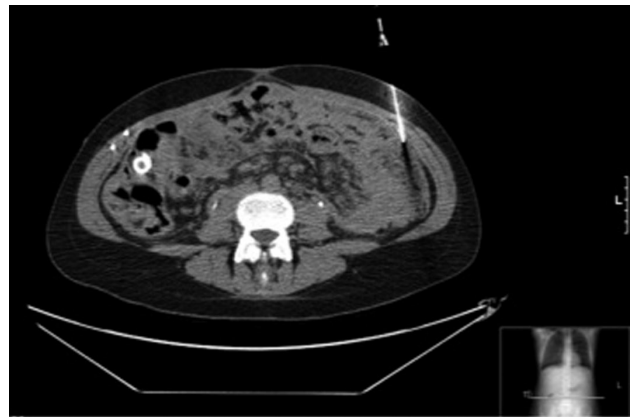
An image of the patient's CT guided omental biopsy.
